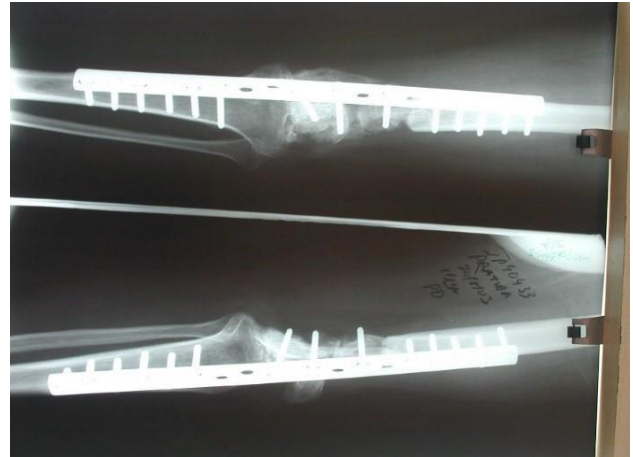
A 18 months post op X-ray of arthrodesis of the knee joint using a long plate and allograft.
